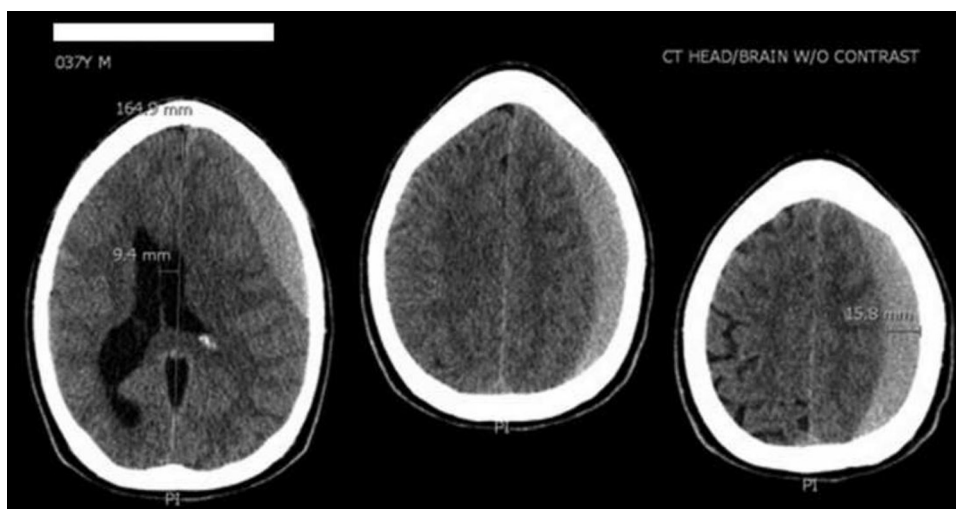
Noncontrast cranial computed tomography image of an acute spontaneous subdural hematoma. There is hyper-dense subdural fluid on the left side with 9 mm of midline shift and no evidence of cranial trauma.
